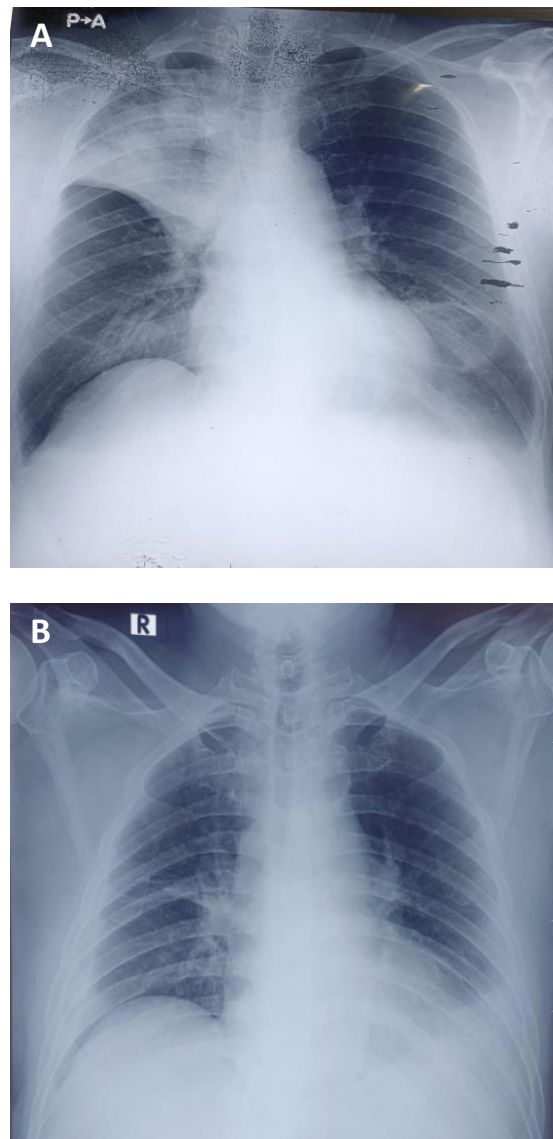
A) Chest X-ray at the start of chemotherapy, demonstrating a shadow in the right upper field, left pleural effusion, and an enlarged cardiac silhouette; B) Chest X-ray, four months after chemotherapy, showing improvement in the right upper lung but persistent left pleural effusion.
